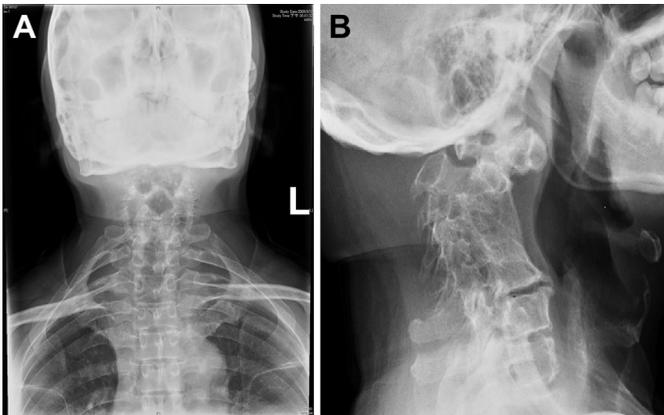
(A) Anteroposterior and (B) lateral radiographs of the cervical spine of a 58-year-old man with type III Klippel-Feil syndrome with atlantoaxial subluxation.
